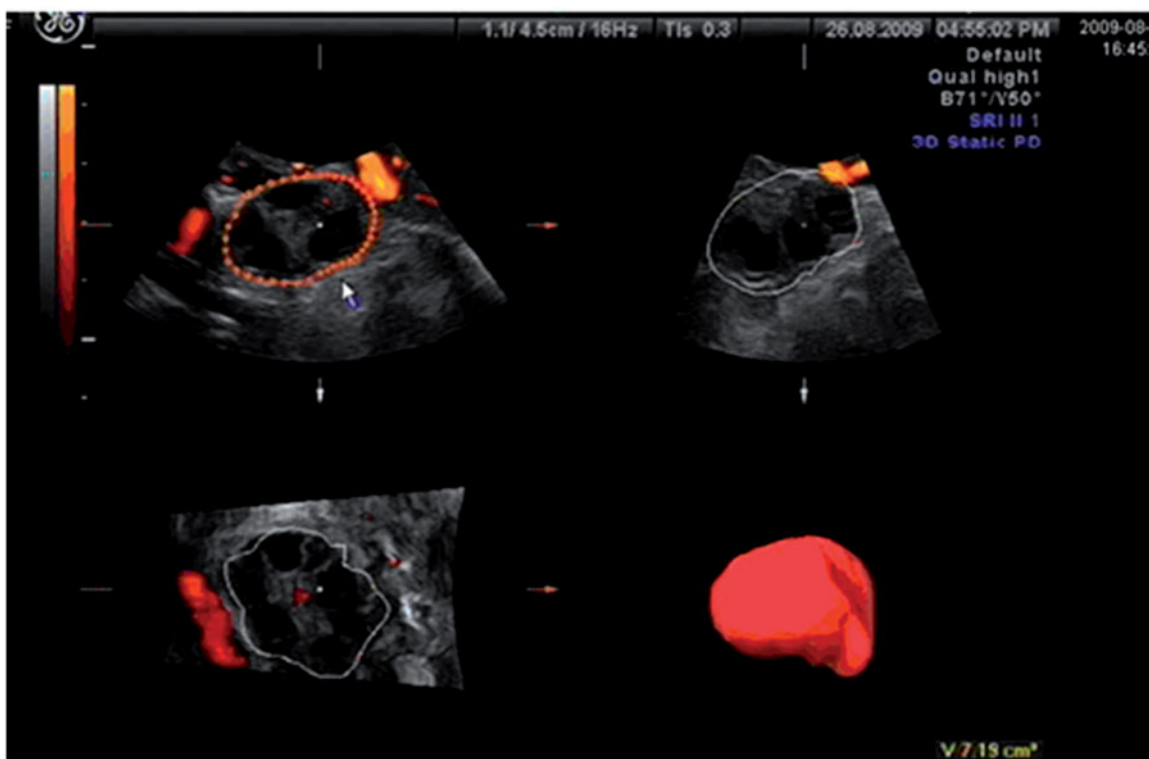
Outline the ovary in manual mode to obtain the 3 D ultrasound volume of ovary.
